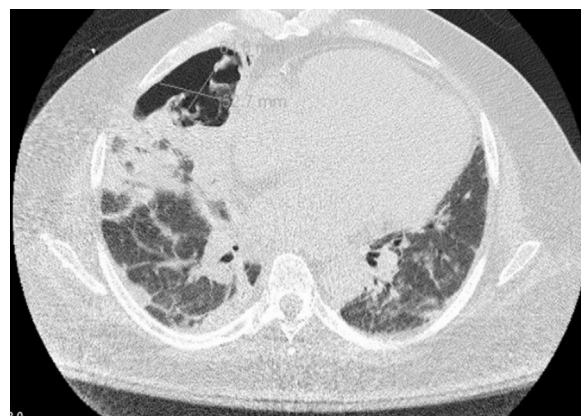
CT scan of the thorax: right lung base consolidation and cavitary lesion with air-crescent sign
